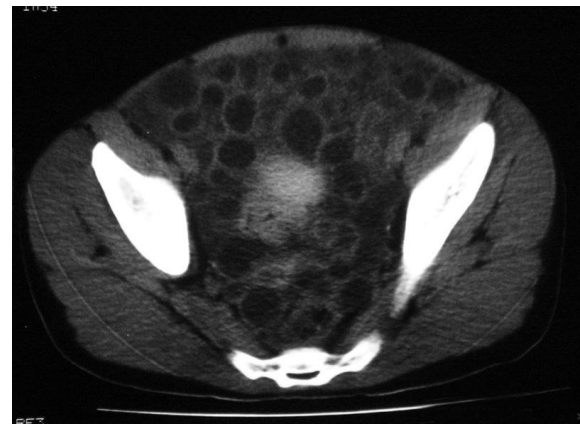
CT-scan showing hydatid cyst in the abdominal cavity involving the liver.
